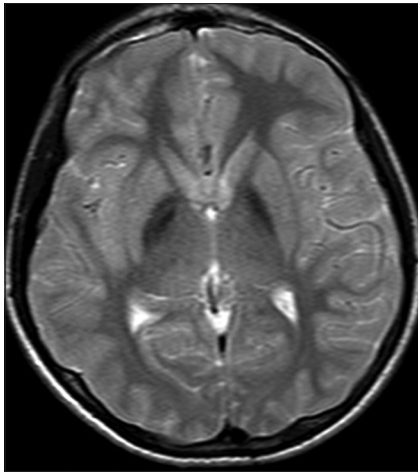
Symmetric, hypointense lesions in the globus pallidus and substantia nigra in T2-weighted images of brain imaging
